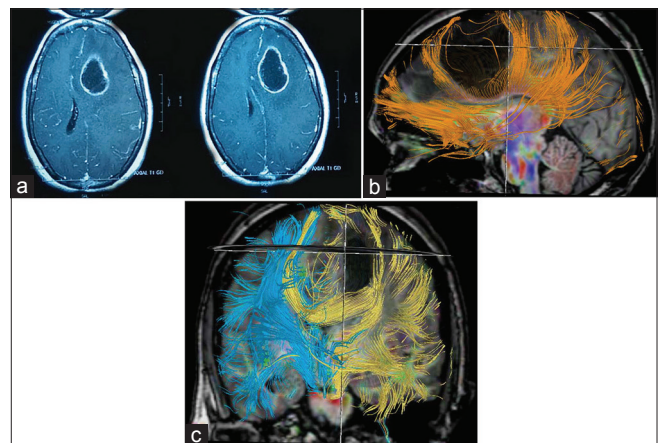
(a) A 50-year-old female patient presented with a headache, language disorder, and cognitive impairment. Magnetic resonance imaging showed the presence of left frontal high-grade gliomas. Diffusion tensor imaging showed displacement of the tracts. Postoperatively, patients show improvement in language and cognitive function. (b) Diffusion tensor imaging (sagittal) showed displacement of tracts. (c) Diffusion tensor imaging (coronal) showed displacement of tracts
